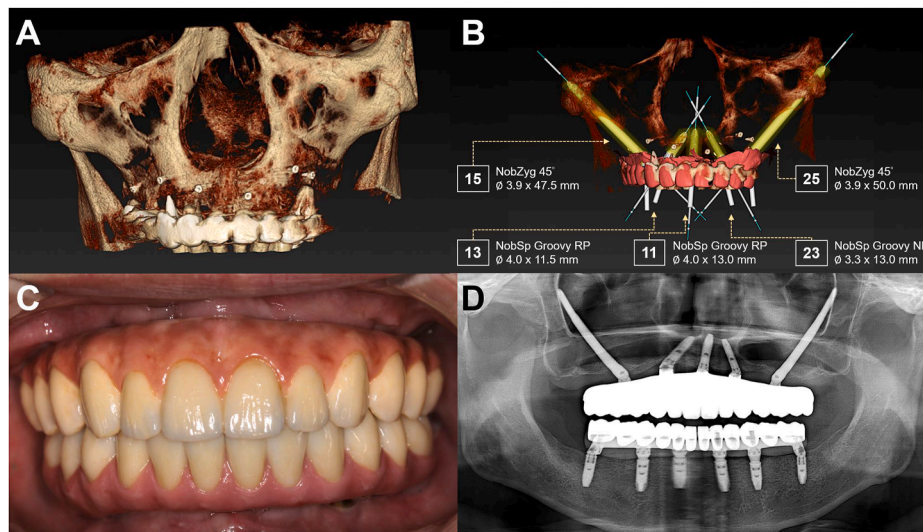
Technical overview of dynamic navigation technology combined with zygomatic implants. (A) The 3D model of the maxillary bone generated from computed tomography images was used for surgical planning. (B) Dental implant size selection and placement were controlled through DTX Studio Implant software. (C) Intraoral photograph showing the final implant-supported complete-arch fixed dental prosthesis (ISCFDP) in place following installation. (D) The final ISCFDP were placed in the mouth to take X-ray images.
